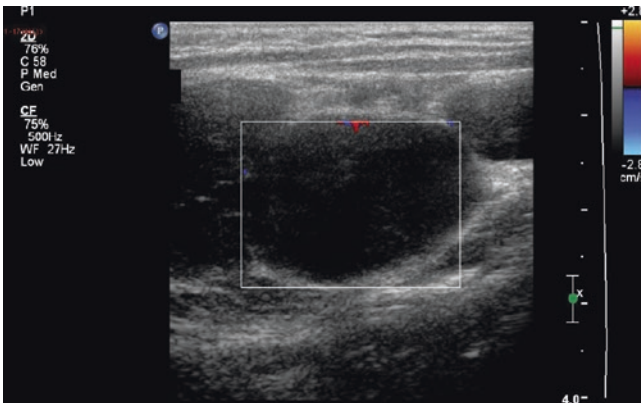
Lymphomatous cervical node on ultrasound. The abnormal enlarged lymph node is round and hypoechoic, with loss of its central echogenic hilum and absence of normal vascularity on colour Doppler
